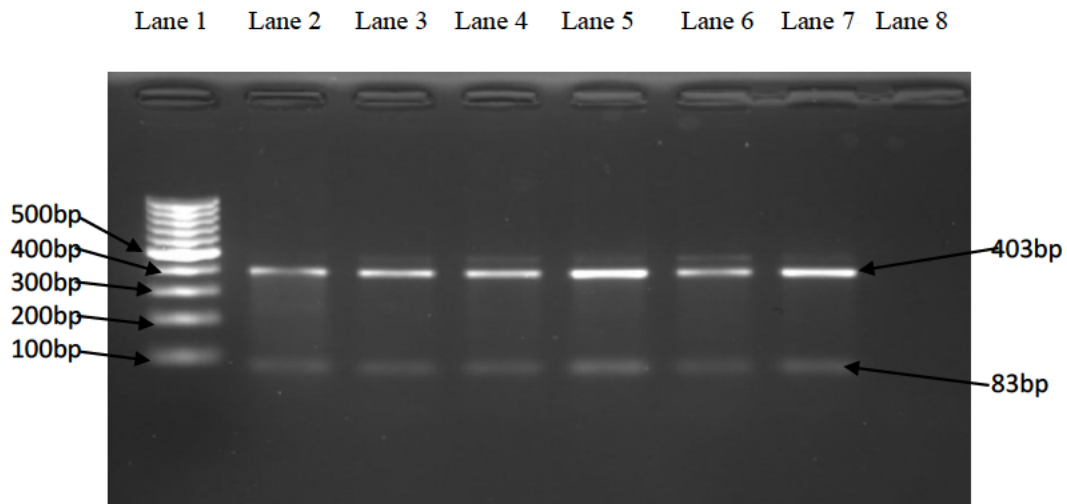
A 2% agarose gel depicting genotyping results of the *MTNR1B* (rs1387153) (C>G / C>T) polymorphism by RFLP-PCR assay. Lane 1:100 bp DNA Ladder (Thermo Scientific, SA). Lane 2 -7: A DNA fragments of 83 and 403 bp indicated homozygous C, T, or heterozygous CT. Lane 8: No template control.
